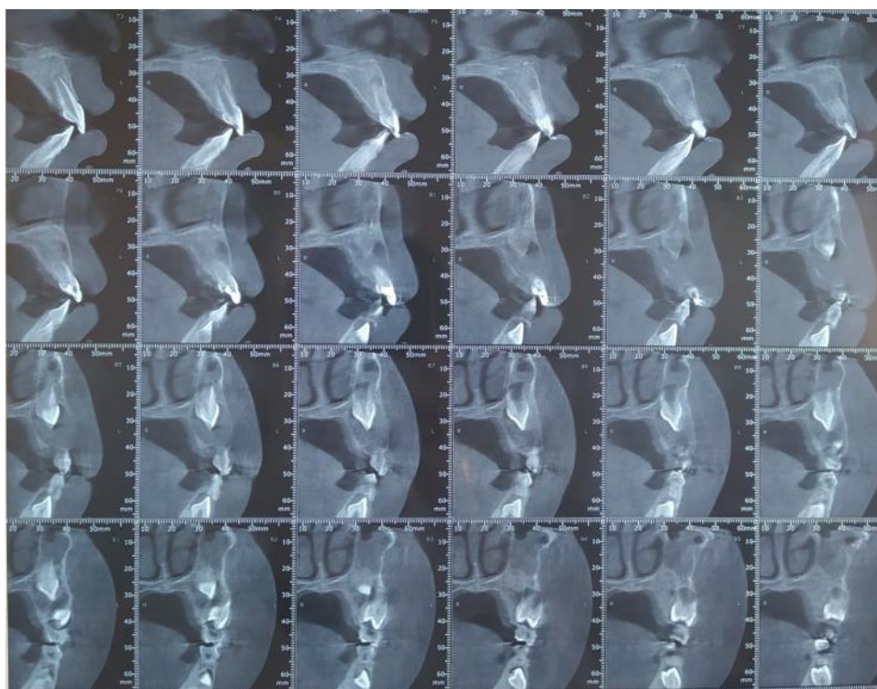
CBCT showing a well-defined radiolucency preserving the integrity of surrounding tissues.
